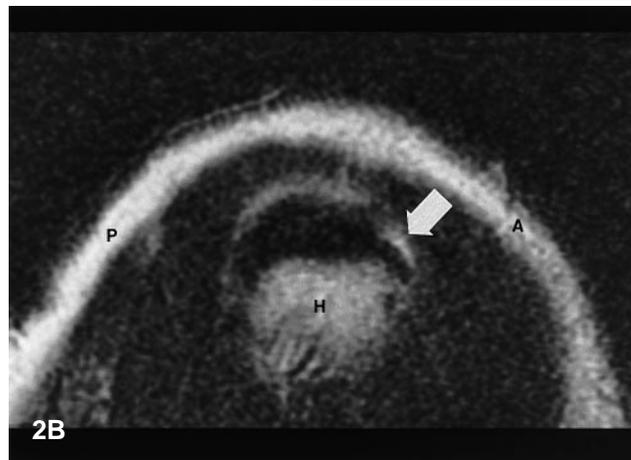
Small full-thickness rotator cuff tear of the anterior portion of the supraspinatus tendon in a 58-year-old man. A Oblique coronal fat-suppressed fast spin-echo T2-weighted [2000/90(eff)] and B oblique sagittal T2-weighted spin-echo (2000/90) MR images show that the tear (*arrows*) extends to the anterior edge of the tendon (*asterisk*) anterior portion of the supraspinatus tendon (*T*). Note the 5 mm cannula (*arrowheads*) entering the joint through the anterior interval. *A* Anterior, *P* posterior, *H* humeral head
